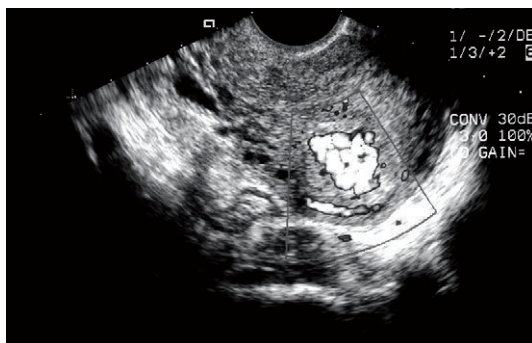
Colour flow Doppler demonstrating extensive vascular abnormality extending from the endometrium deep within the myometrium. This was an arteriovenous malformation which required embolisation but similar patterns may be seen in some cases of trophoblastic involution, particularly following termination of pregnancy.
